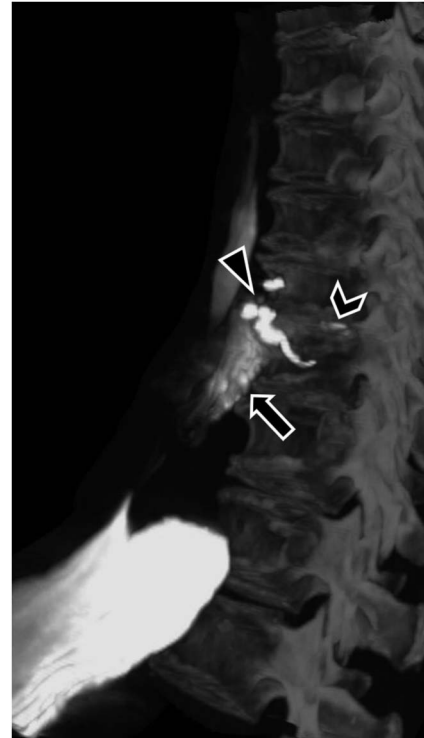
3D maximum-intensity projection reconstructed from thoracic spine CT images demonstrates persistent prevertebral fluid collection (arrow) with contrast within the intervertebral disk (chevron). Embolization coils are seen in the prevertebral space superior to ulceration (arrowhead). Residual oral contrast is seen within the esophagus and stomach. CT, computed tomography.
